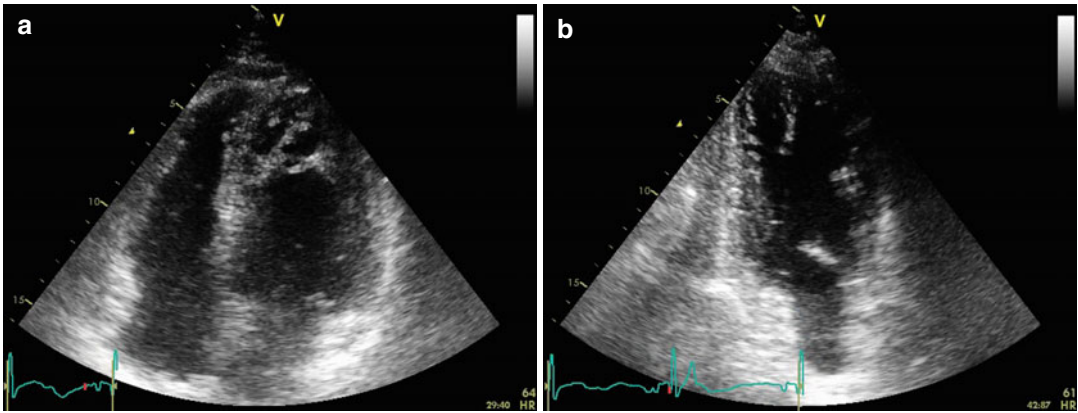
Echocardiogram: (a) apical four-chamber view. The marked trabeculae of the apex can be noticed. (b) Apical two-chamber view. Apex trabeculae are visible also in this view
